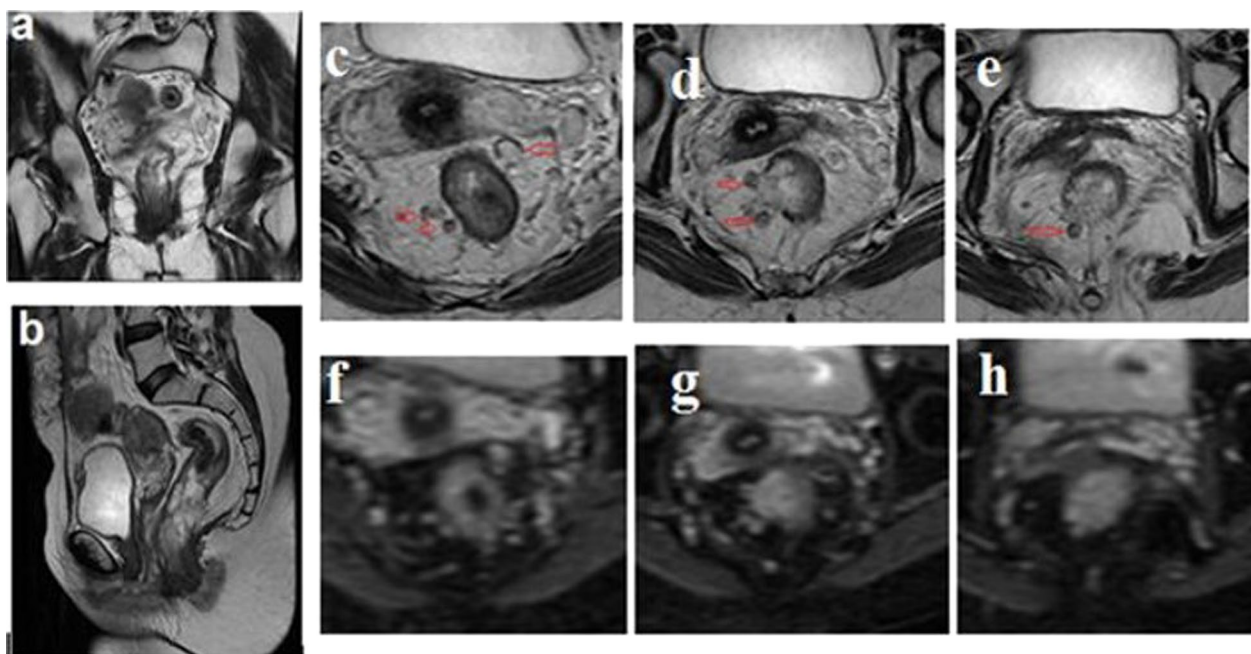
a–h MRI study for 40 years old Female with pathologically proven cancer rectum and received radiotherapy. a, b coronal and Sagittal T2 WIs, c–e axial T2 & f–h DWIs, revealed irregular polypoidal mural thickening is seen involving the lower 2/3 of the rectum, involving the anorectal junction; with surrounding fat smudging; however no evidence of MRF infiltration with clear intervening fat plans. The lesion displays mixed T2 signal with the intermediate signal representing the tumoral residual while the hypointense signal denoting fibrotic changes. Multiple enlarged mesorectal and internal iliac lymph nodes are seen measuring up to 1.2 cm, displaying intermediate T2 and mild hyperintense signal on DWIs
